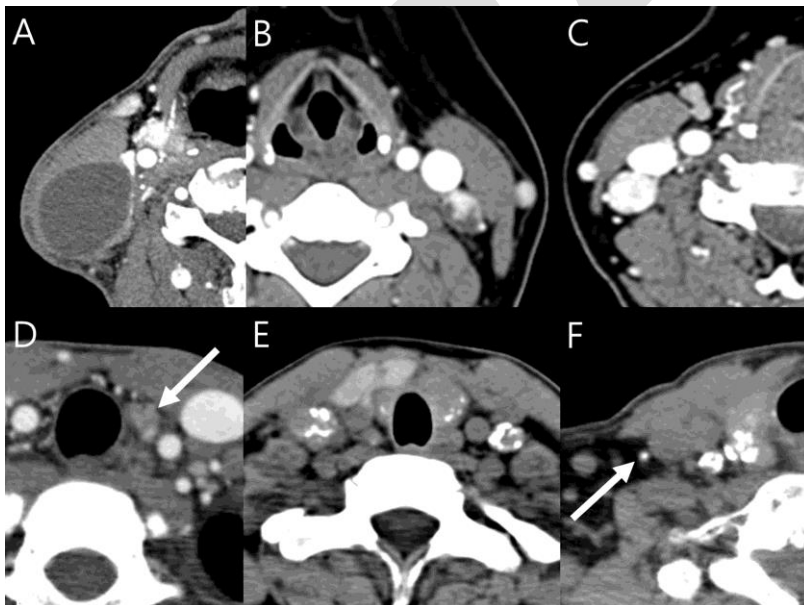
Suspicious lymph nodes (CT features). A, A large nonenhancing cystic nodal mass. B, A small focal cystic change and a strong enhancement in the lymph node. C, A diffuse, strong enhancement in the lymph node. D, A heterogeneous mild enhancement in the lymph node. E, F. Multiple variable-sized nodal calcifications and a tiny nodal calcification (F, arrow) on an
